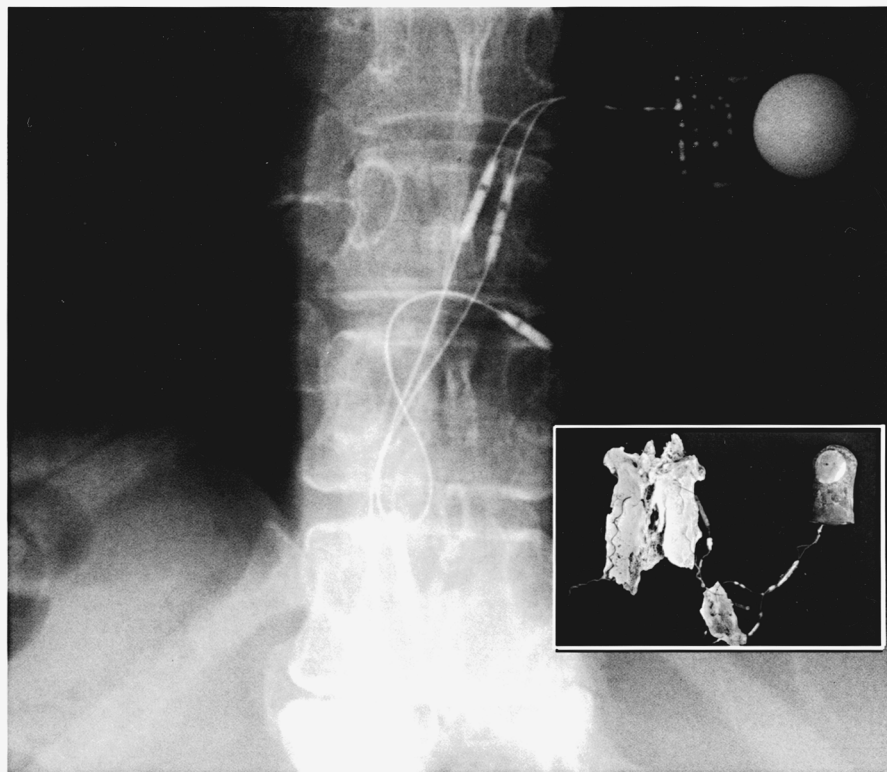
Comparison of antemortem radiograph and recovered incinerated Osteostimulator.
